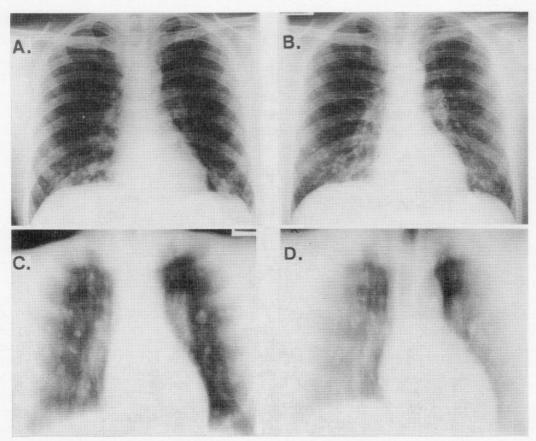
The chest X-ray film (A, B) and tomography (C, D) of the patient. Left (A, C); the X-rays were taken in 1983. Right (B, D); the films were taken in 1990. Multiple metastatic lesions are seen in the field of both lungs.
